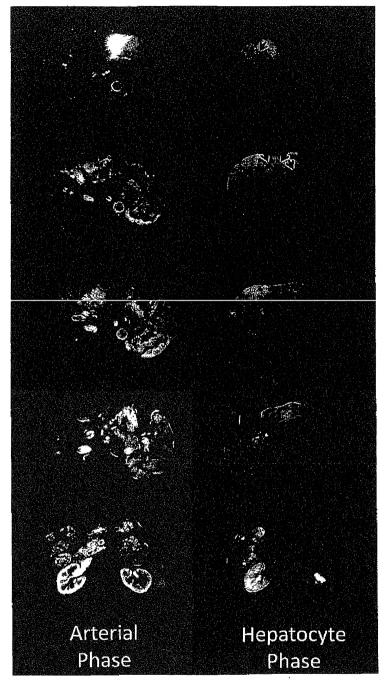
Gd-EOB-MRI Gd-EOB-MRI showed multiple tumors which were enhanced in arterial phase, and became the lesions with low intensity in hepatocyte phase. Portal vein was observed running through the S3 tumor. (arrow)
